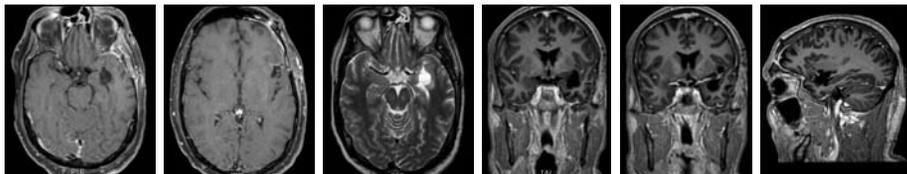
Postoperative MR imaging reveals gross total (more than 95%) resection of the tumor and resolution of pressure on the left lateral ventricle.
